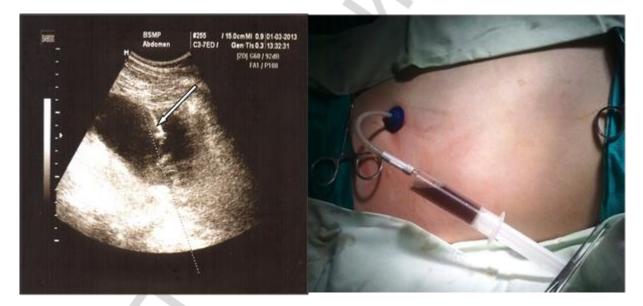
Percutaneous catheter drainage under ultrasound guidance
